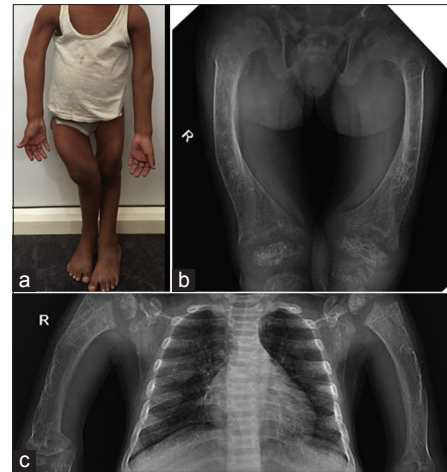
(a, b and c) Deformities of bilateral upper and lower limbs with radiograph showing ground-glass appearance of fibrous dysplasia
